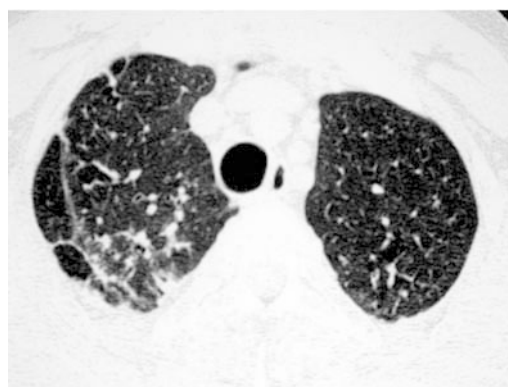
Chest HRCT of a 40-year-old man (16 years' disease duration) demonstrating apical fibrosis, parenchymal bands and subpleural emphysema
